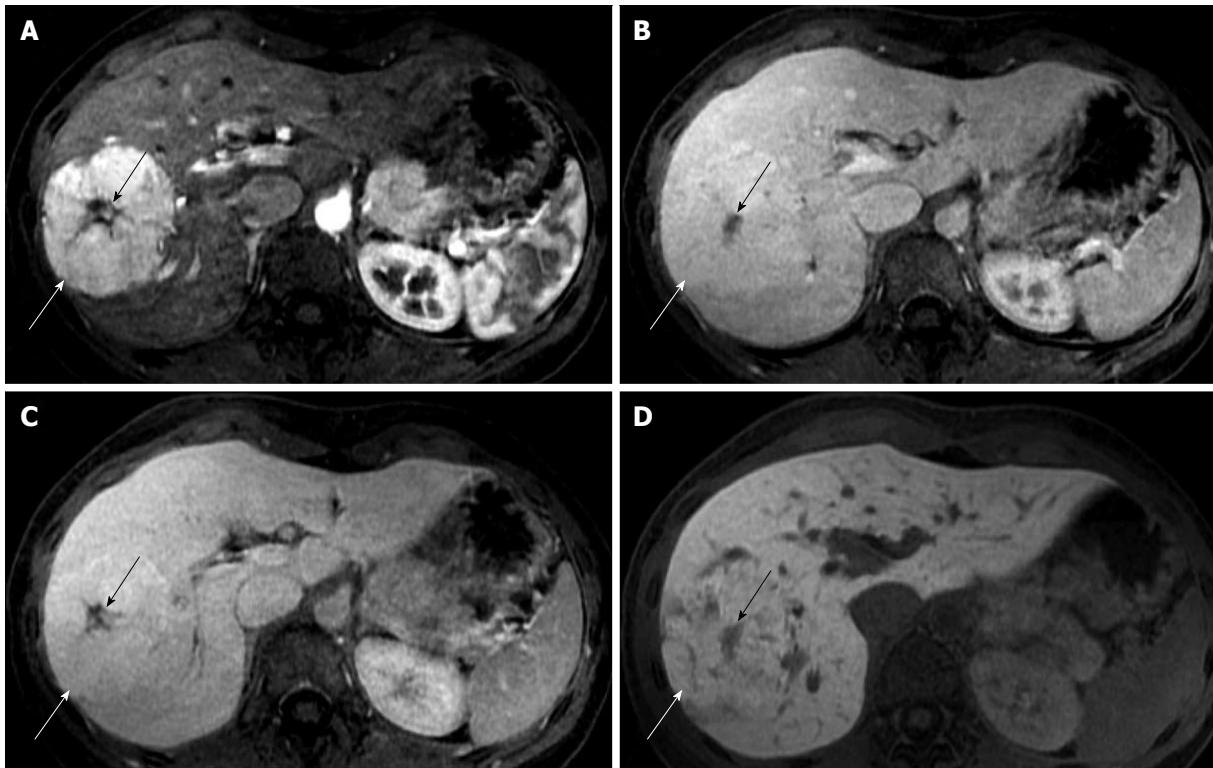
Typical imaging features of focal nodular hyperplasia in a 29-year-old woman. Gadoxetic acid-enhanced magnetic resonance imaging; axial images (A-D) were obtained in dynamic phases and hepatobiliary phase. A shows a solid circumscribed mass (white arrow), lobulated in contour, with a central scar (black arrow); the lesion is hyperintense on the arterial phase (A) and persists slightly hyperintense in the portal and venous phases (B and C respectively). In hepatobiliary phase (D) the mass is slightly hyperintense or isointense to the surrounding liver. The presence of biliary canaliculi, even if not functioning, leads to retention of gadoxetic acid in comparison to the surrounding parenchyma.
